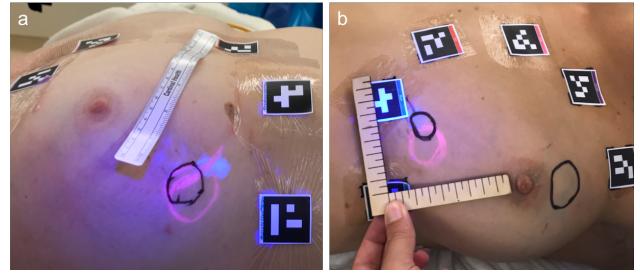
Tumor markings made in two example patients (pink = cognitive fusion, blue = HoloLens, black = palpation). a) In this patient, the HoloLens marking is displaced partly due to discrepancies in patient arm position between the MRI and the surgical position. b) In this patient, the palpating surgeon initially marked a lesion in a different region of the breast, which may have been benign. This example shows how important it is for surgeons to have access to additional technologies to identify malignant tumors.
